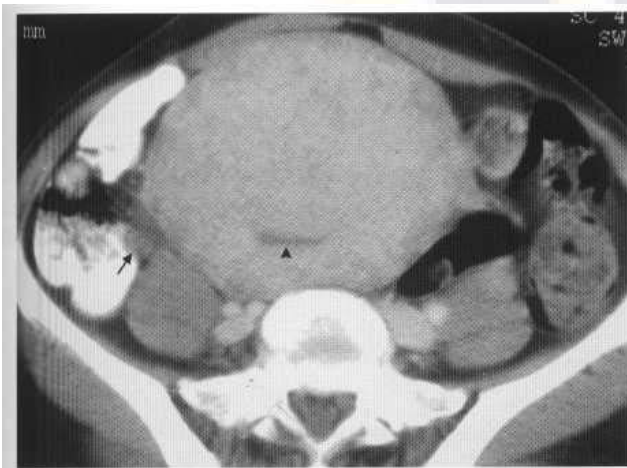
CT. Bulky mildly heterogeneous uterus with posterior displacement of the cavity due to adenomyosis rather than fibroids.
